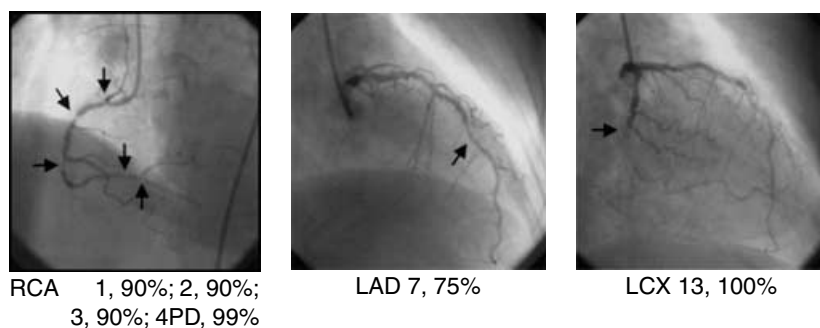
A hemodialysis patient of 75-year-old woman showing triple-vessel disease by coronary angiography and differences in imaging between BMIPP and TI singlephoton emission computed tomography (SPECT). Abbreviations are: RCA, right coronary artery, PD, posterior descending branch, LAD, left anterior descending artery; LCX, left circumflex artery.
